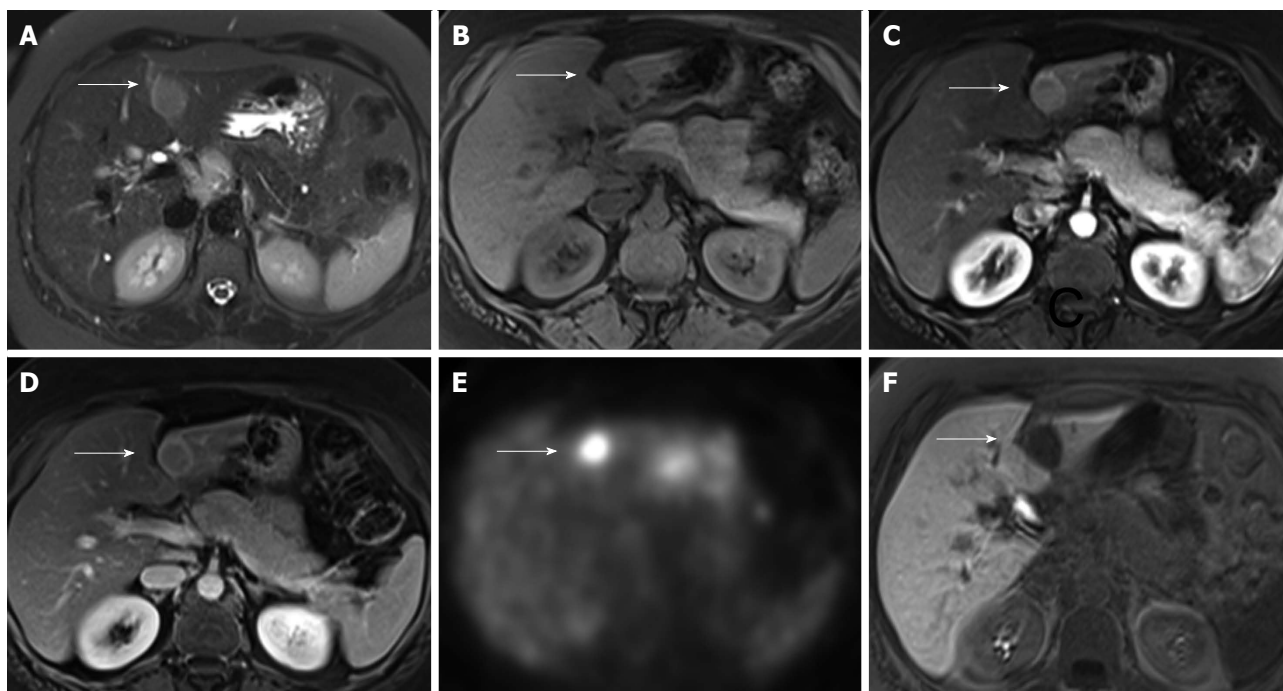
Imaging findings of case 1. A: T2-weighted fat-saturated image showing focal mass (indicated by arrow) in segment 2 with increased signal intensity as compared to background liver; B: T1-weighted fat-saturated image showing focal mass with decreased signal intensity as compared to background liver; C: T1-weighted fat-saturated image after contrast infusion in the late arterial phase. The mass is hypervascular on this phase; D: T1-weighted fat-saturated image after contrast infusion in the portal venous phase. The mass washes out on this phase. A capsule is seen; E: Positron emission tomography scan shows hypermetabolic activity; F: T1-weighted fat-saturated image 20 min after hepatocellular contrast, Gadoxetate Disodium (Eovist) infusion. Lesion does not take up Eovist.
